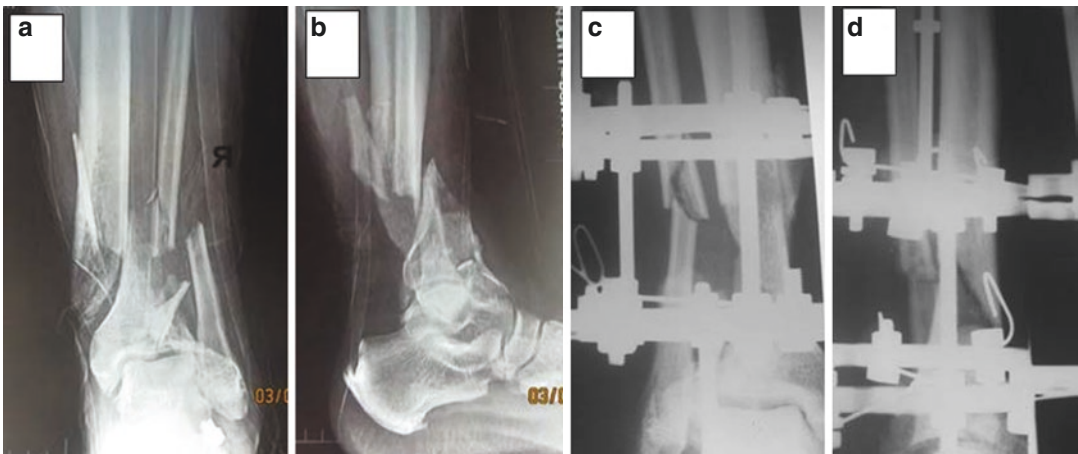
(a) Anteroposterior radiograph before operation, (b) lateral radiograph before operation, (c) anteroposterior radiograph after operation, (d) lateral radiograph after operation
